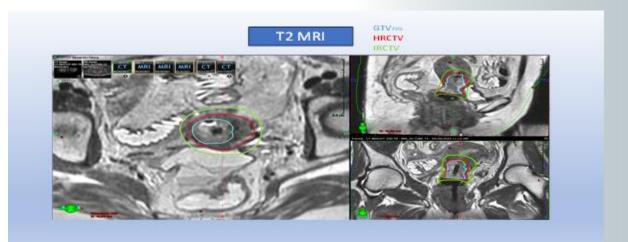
The GTV-Tres (cyan) seen as high signal intensitity on T2 MRI. The CTV-THR (red) contoured as GTV-Tres along with entire cervix and extra cervical tumor extension. The CTV-TIR (green) contoured by giving margin to CTV-THR and excluding from OAR'S to replicate disease at the time of diagnosis
